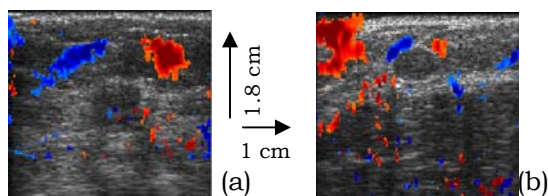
Examples showing the axial-shear strain elastogram (color patches, see CD version) superimposed on the corresponding sonogram of a cancer (a) and a benign lesion (b). Observe that the proximity of the axial-shear strain region to the sonographically visible lesion is different for both the cases.
